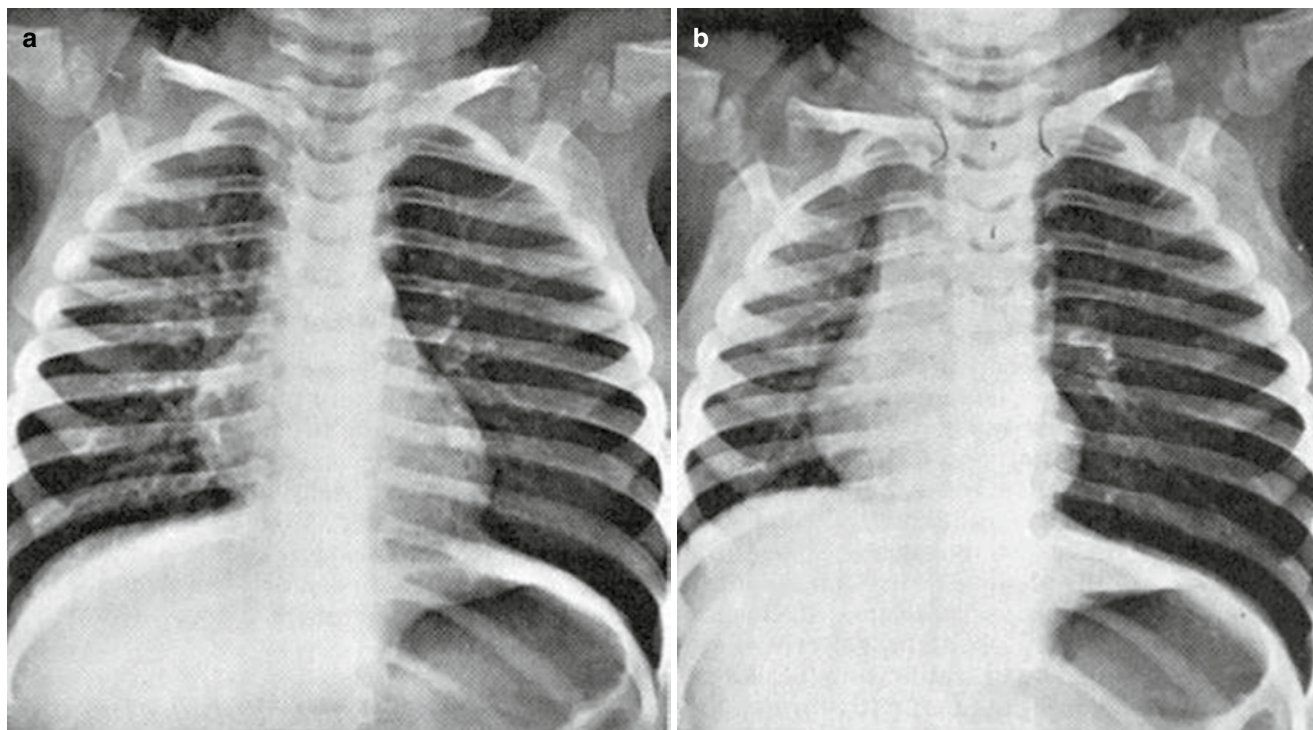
Foreign body aspiration. Inspiratory and expiratory chest radiographs demonstrate hyperinflation due to a peanut fragment in the left mainstem bronchus. (a) The inspiratory film appears relatively
